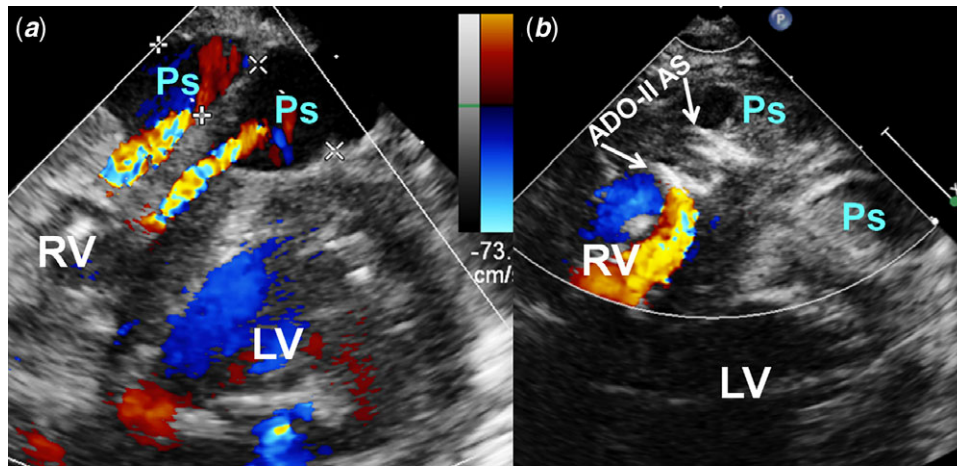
Transthoracic echocardiograms. (a) Two large pseudoaneurysms with forward flow at colour Doppler in the short-axis view. (b) Two large pseudoaneurysms were embolised using a closure device (arrow) and were completely thrombosed. ADO-II AS = Amplatzer Duct Occluder II Additional Sizes; LV = left ventricle; Ps = pseudoaneurysms; RV = right ventricle.
